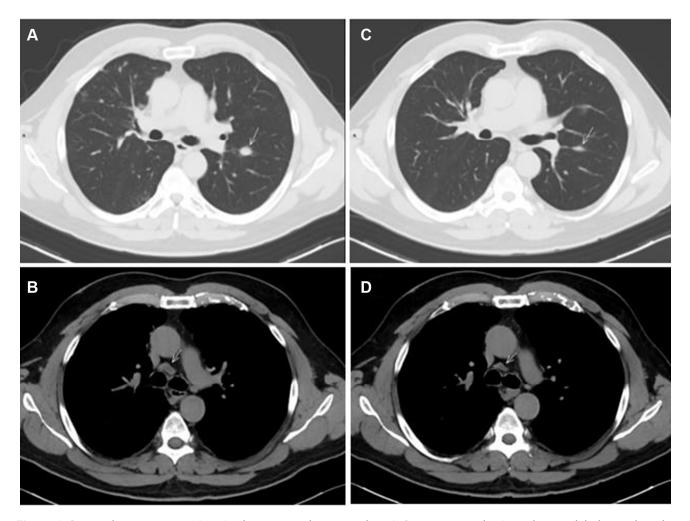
Pre- and posttreatment imaging by computed tomography. (A) Pretreatment dominant lung nodule located on the left lung fissure and (B) largest lymph node located in right parabronchial mediastinum. Consecutive computed tomography images posttreatment with decrease in size of lung nodule (C) and mediastinal lymph node (D).
